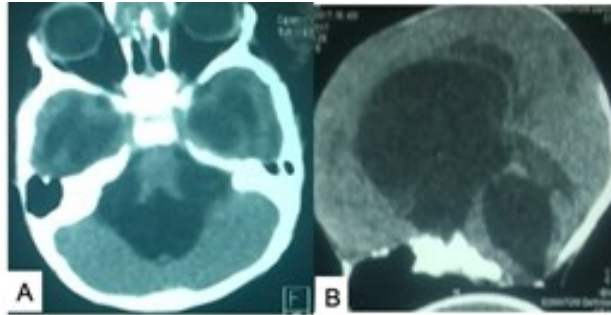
CT scan of the head (A) axial and (B) sagittal views) showing fourth-ventricular obstruction (FVOO) due to foramen Magendie and Luschka atresia. Source: Figure by authors.
